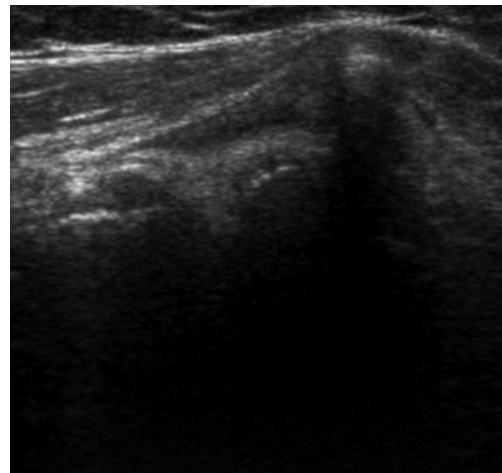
Calcification of tendon of supraspinatus as seen on ultrasonography
